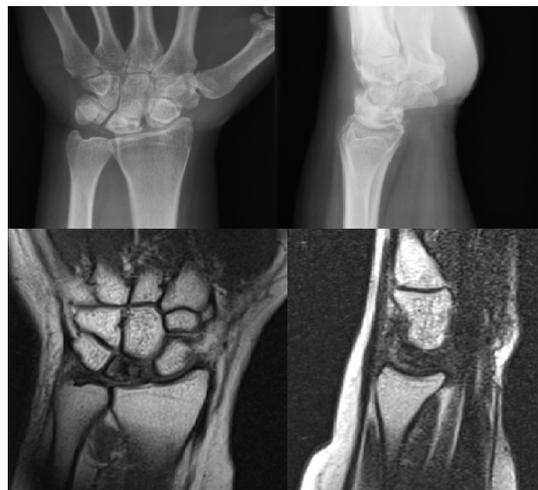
Preoperative radiographs and MRI showing collapse of the lunate, with preservation of carpal height and intercarpal alignment
